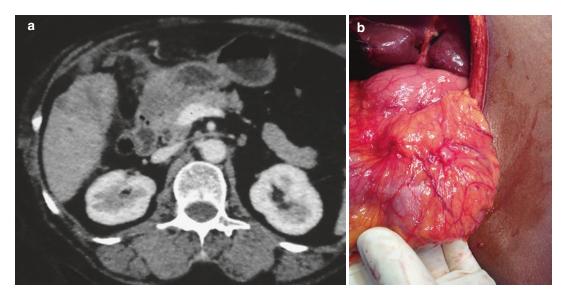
Omental metastatic nodule (a) on CT (b) at operation
